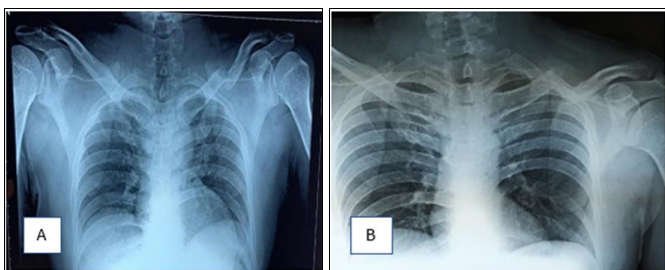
Patient treated conservatively A) Initial radiograph of the fracture at presentation B) Fracture union after 6 months of conservative management
